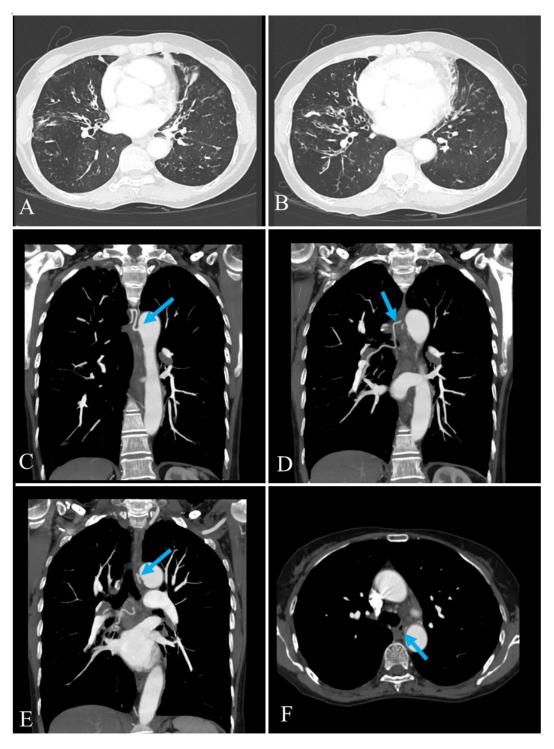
Multi-detector computed tomography CT angiography (CTA) with lung window reconstruction in axial view (A) and (B) demonstrates bilateral lungs bronchiectasis predominantly involving right lower lobe, middle lobe and lingular segment of left upper lobe. CTA with maximum intensity projection revealed type IV bronchial arteries anatomy: 2 right bronchial arteries and 1 left bronchial artery. The 2 right bronchial arteries are dilated ranging 2-3mm in diameter with tortuous course distally (arrows in (C), (D) and (E)). The left bronchial artery is normal in size measuring 1.5mm and no evidence of aneurysm (F).
